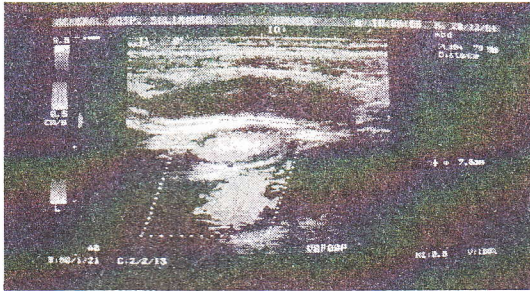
ultrasound finding of acute appendicitis
